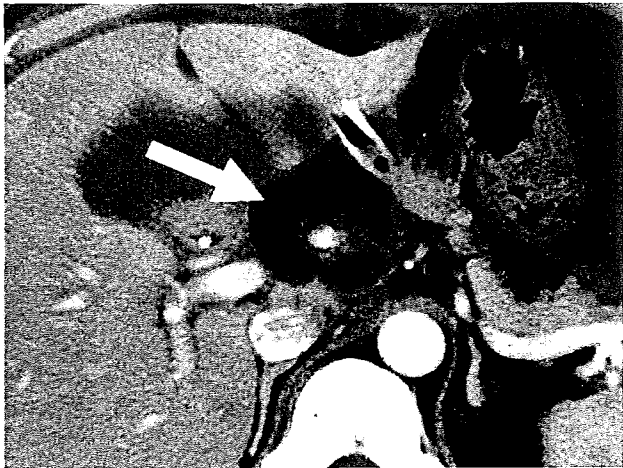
Postoperative CT scan showing the wrapped hepatic artery after a pancreaticoduodenectomy. The postoperative CT scan revealed a thick fat-density area, corresponding to the falciform ligament (white arrow), that completely wrapped a well-enhanced vessel, the hepatic artery. The drain was placed on the superior edge of the pancreaticojejunostomy.
